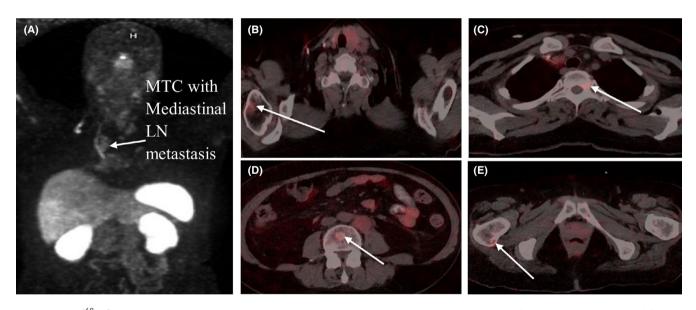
[⁶⁸Ga]-DOTATATE PET/CT demonstrated new bone metastatic lesions in the right humerus (B), 3rd thoracic vertebra (C), 4th lumbar vertebra (D) and right femur (E) in a patient with medullary thyroid cancer with liver and lymph node metastasis (A) [Colour figure can be viewed at wileyonlinelibrary.com]
